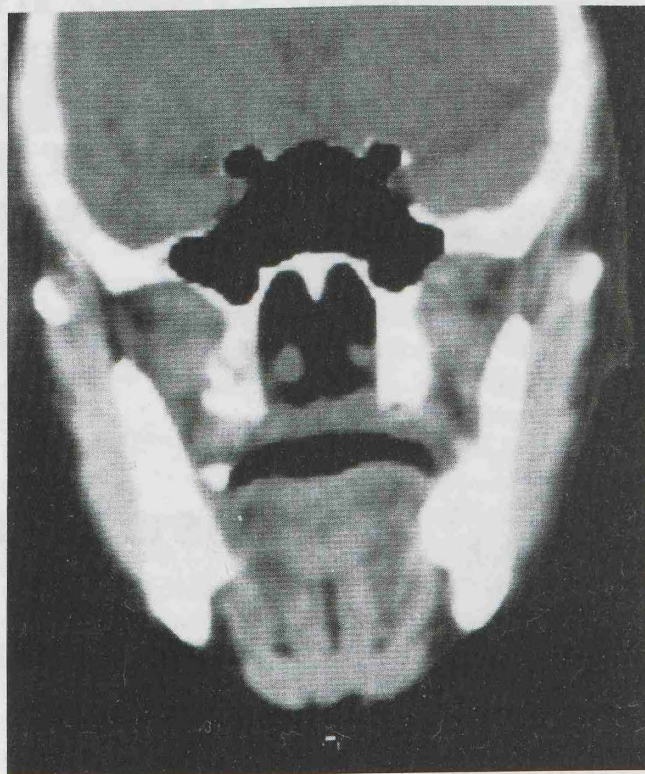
Cranial CT displaying a giant sphenoid sinus with a bulging of the carotid arteries in the lateral walls.
